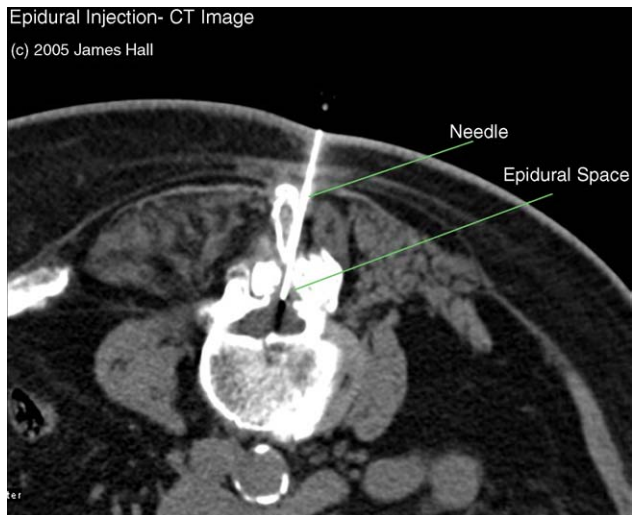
Computed tomography (CT) slice of spinal needle placed into epidural space of spine to inject mixture of local anesthetic and corticosteroid medications.
